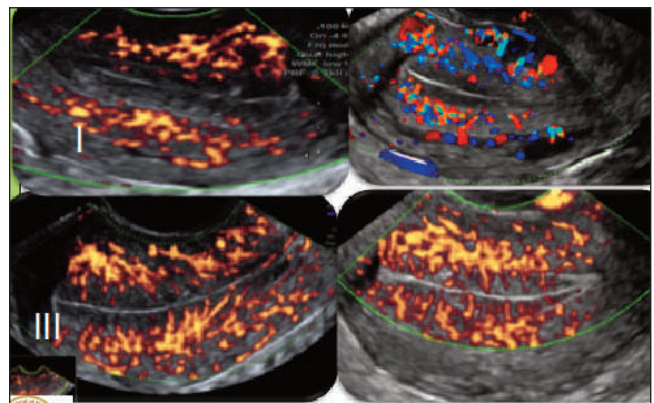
Power Doppler images of the grade 1-4 endometrial vascularity
